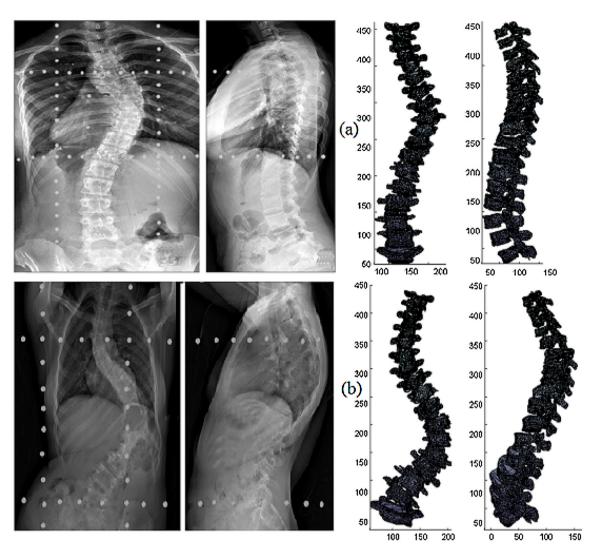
Bi-planar X-rays and corresponding CSCPG reconstruction (a) subject-1 (b) subject-2.
